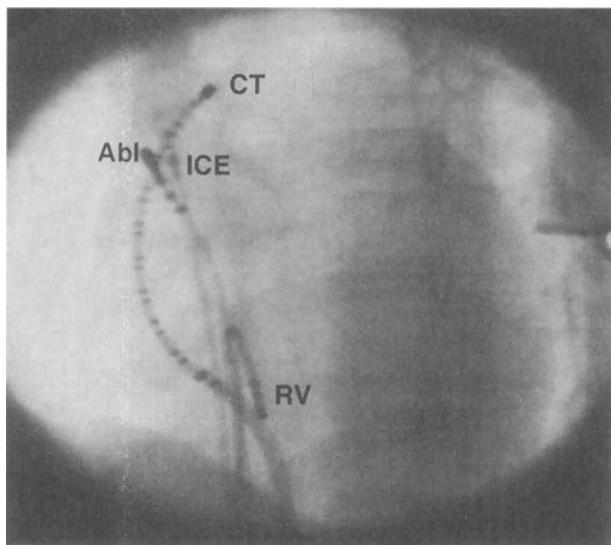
Technique used for radiofrequency catheter modification of the sinus node. The figure shows placement of the multipolar electrode catheter against the crista terminalis (CT). This structure is readily visualised by intracardiac echo guidance. Also shown is the position of the ablation catheter (Abl), the multipolar electrode catheter (CT) and the intracardiac echo probe (ICE). (By permission from ref. 19.)
